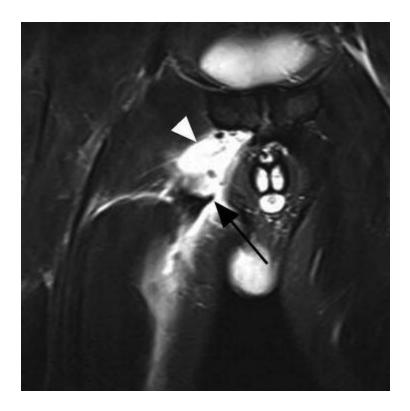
A 21-year-old male javelin thrower presenting with a sudden onset of right-sided groin pain secondary to an avulsion injury. Coronal fat-suppressed T2-weighted MRI demonstrates a wavy appearance and retraction of the torn end of adductor longus tendon (*arrow*) with surrounding fluid-equivalent hyperintensity representing hematoma (*arrowhead*). Small hypointense fragments of avulsed cortical bone from the symphyseal attachment are also noted
